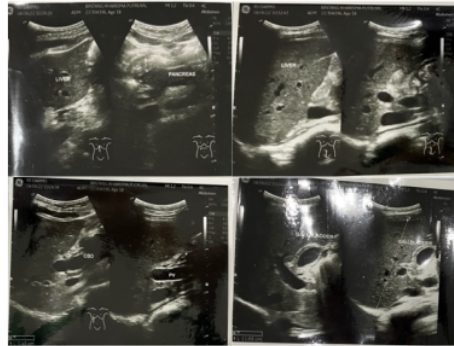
The abdominal ultrasonography revealed mild hepatomegaly with slightly decreased overall echotexture echogenicity. The portal venous flow, gall bladder, and extrahepatic bile ducts were unremarkable. The remainder of the abdominal ultrasonography was also unremarkable.
